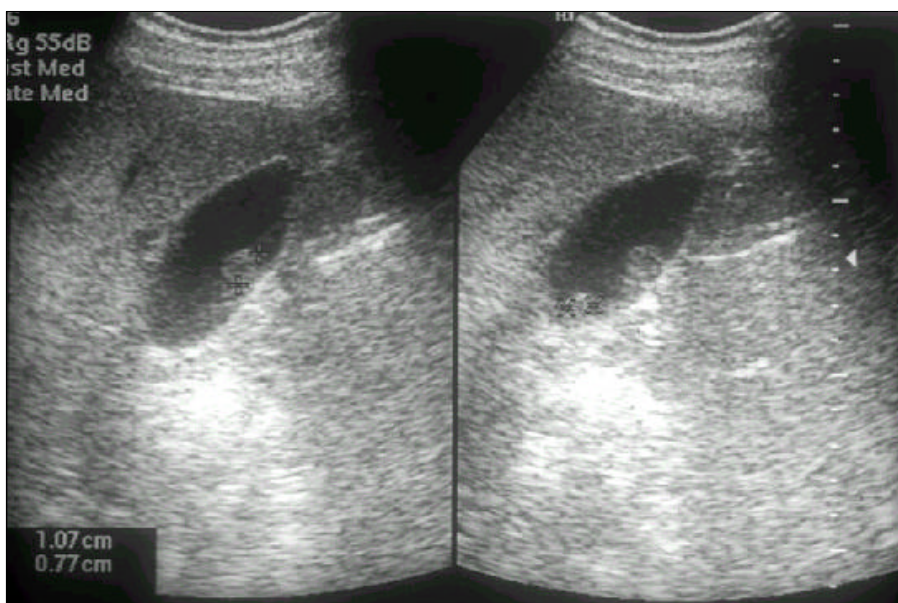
Abdominal ultrasound showing a solid polypoid mass in the gallbladder.
